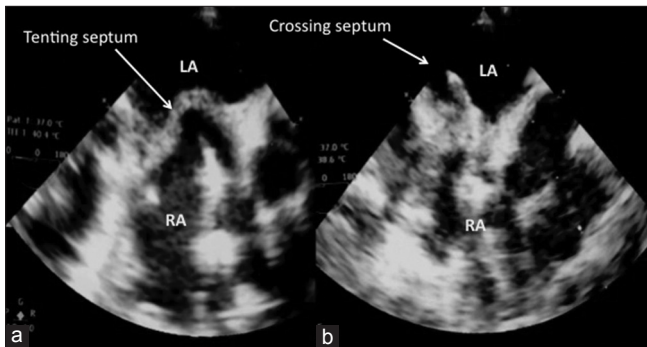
Intraoperative transesophageal echocardiography of the procedure: The tips of the scissors are shown tenting the inter-atrial septum (a) and subsequently passing into the left atrium (LA) through the atrial septum (b)
